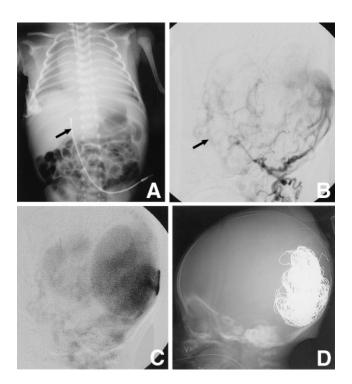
A: Chest radiograph on the day of birth (day 0) showing an enlarged heart with cardiothoracic ratio of 71%. Arrow indicates the catheter in the umbilical vein. B, C: Left retrograde radial angiograms (lateral views, early and late phases) on day 0 showing a huge dural pouch fed by a meningeal branch of left vertebral artery. The left middle meningeal artery is barely visualized (arrow). D: Radiograph (lateral view) after transvenous coil embolization on day 1 showing deposited coils in the huge venous pouch.
